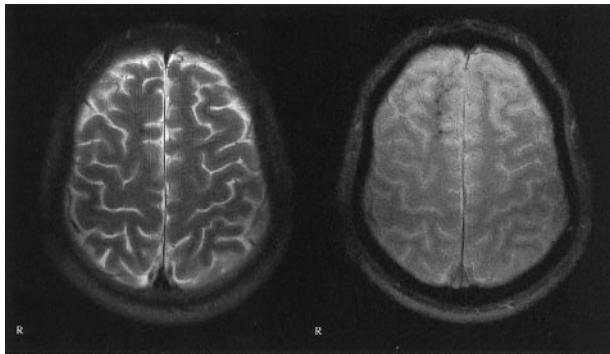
Images of a 20-year-old man who was a passenger in a traffic accident in May 1999; he had not been wearing a seat belt. Multiple traumatic microbleeds are shown in the white matter of the right superior frontal gyrus. *Left*, T2-weighted image; *right*, T2*-weighted image. Axial view sections obtained from the identical location. Multiple traumatic microbleeds, which are clearly shown on the T2*-weighted gradient-echo images, are not depicted on the T2-weighted MR images. Note that no T2-hyperintense foci are seen. GCS score, 3; GOS score, 5.
